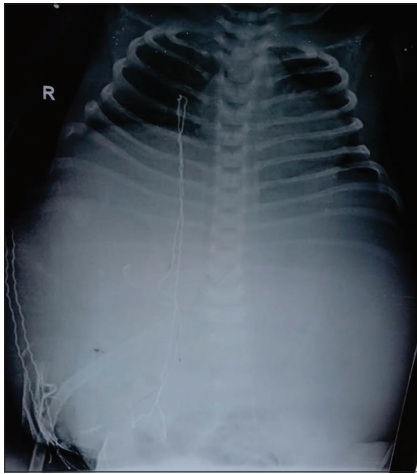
X-Ray chest and abdomen showing ground glass appearance of massively distended abdomen and raised diaphragm
